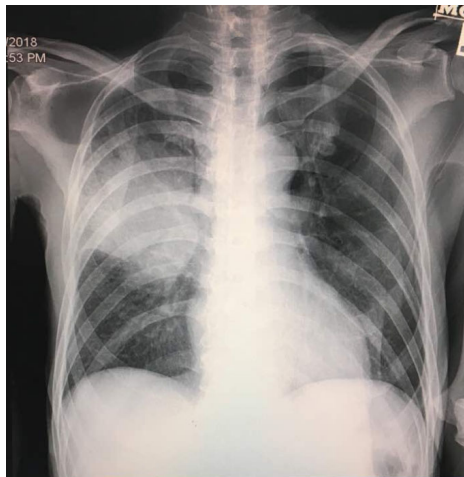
Chest x-ray shows suspicious mass in the right upper and middle lobes.
